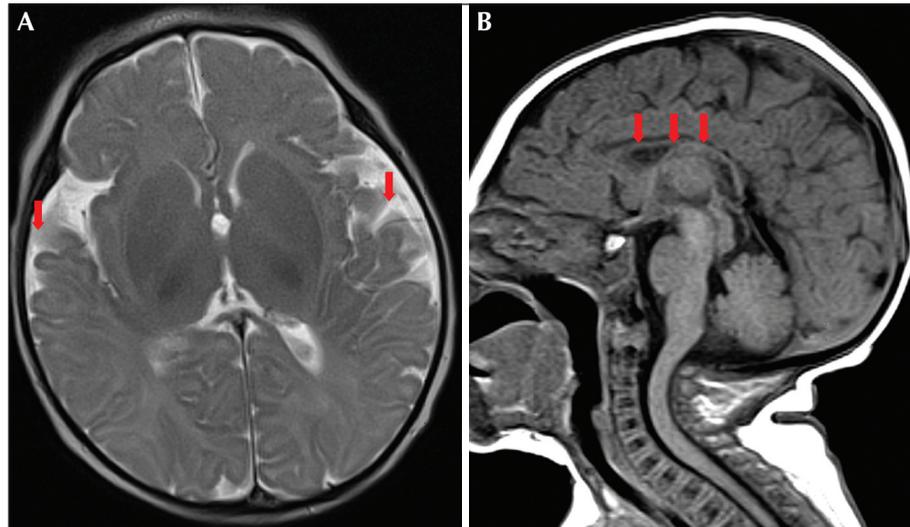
(A) Axial T2 brain MRI showing thinning of the corpus callosum. (B) Sagittal T1 brain MRI showing a widened subarachnoid space.
